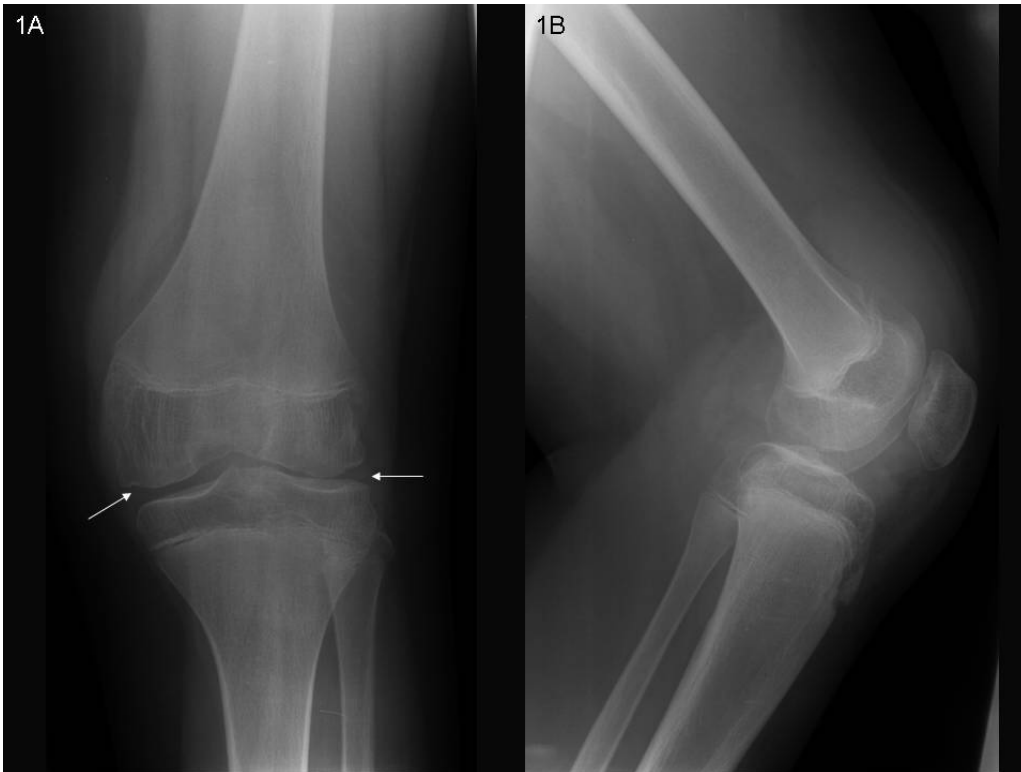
Conventional x-ray of the left knee (same examination date as MRI) with subchondral erosions of both femor condyles and thinning of the lateral joint space.
